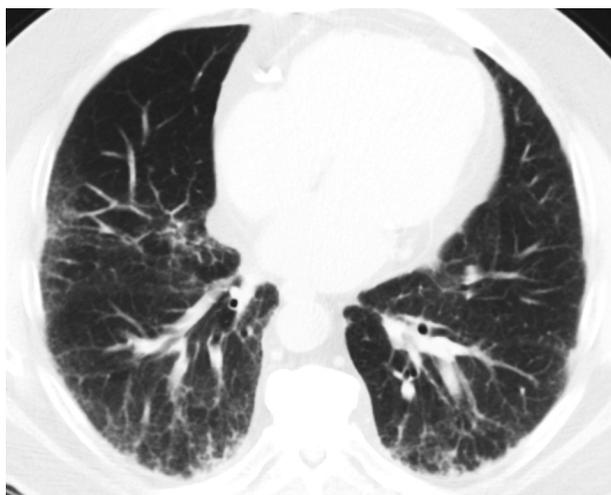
An axial view of high-resolution computed tomography demonstrates a portion of lower lung fields with classic findings of usual interstitial pneumonia characterized by peripherally accentuated reticular densities and honeycomb changes.
